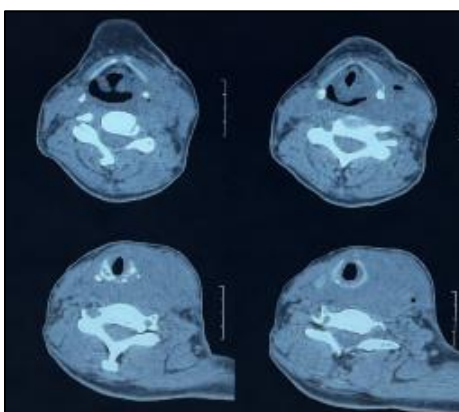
Follow-up cervical CT scan demonstrating a locally invasive left posterolateral cervical mass associated with regional lymphadenopathy
